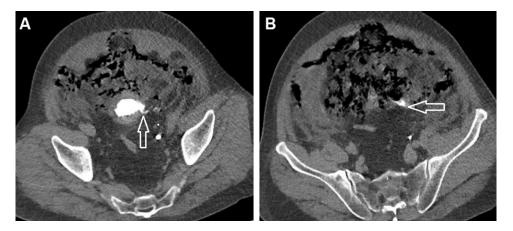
Delayed phase CT showing the interruption of the bladder wall (A, arrow) and extravasation into the extraperitoneal space (B, arrow)
